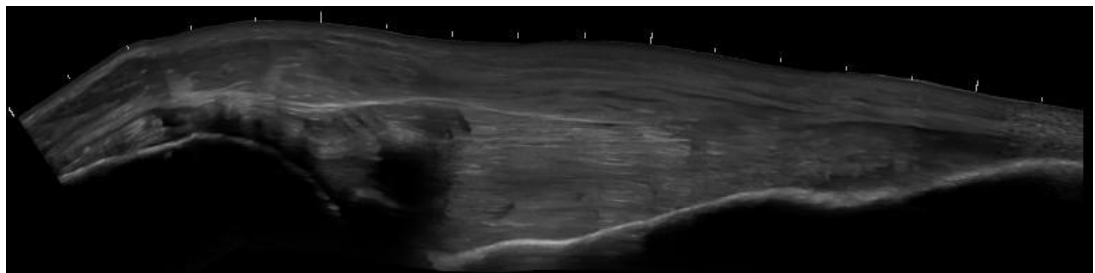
Musculoskeletal ultrasound image, which was collected from cadaver (right shoulder region).
